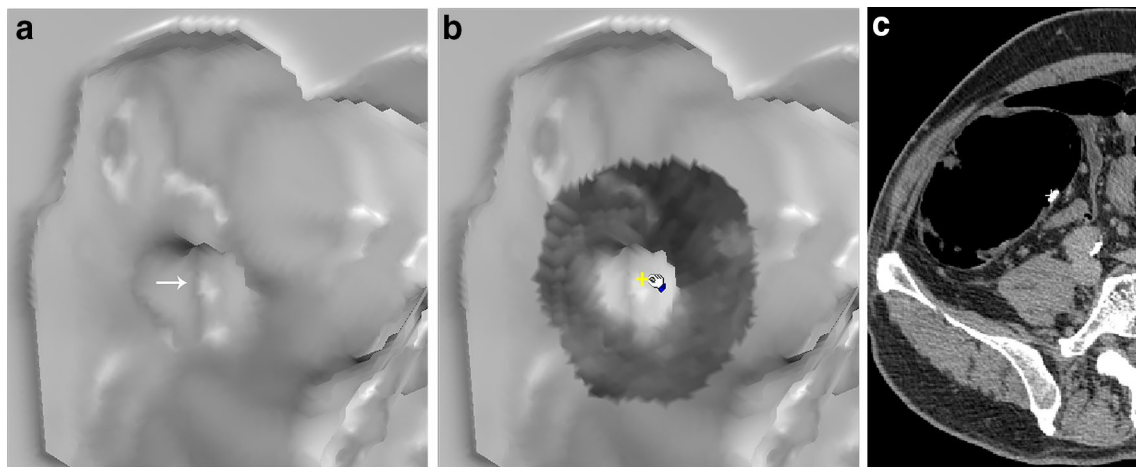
A 60-year-old man underwent CT scanning due to sigmoid colon cancer found by colonography. CTC reveals a polypoid lesion in the ascending colon. Comparison of SR and TGM of the polypoid lesion on CTC. a Traditional SR of CTC shows a polypoid lesion
